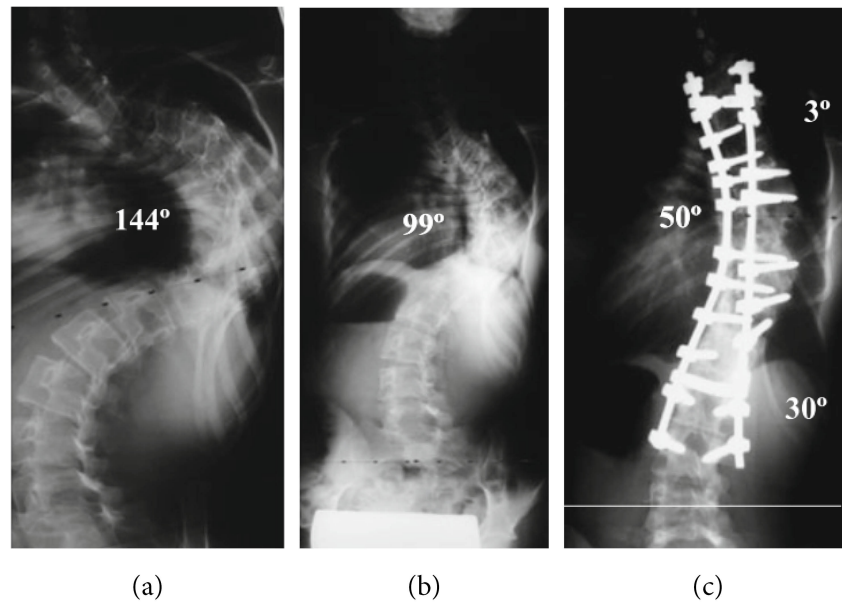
(a) Severe scoliosis with a Cobb angle of 144° . An 'S-shaped' curve is clearly visible in the coronal plane. (b) Reduction of the Cobb angle due to HGT pre-operative to surgery. (c) 3 year follow-up result of spondylosis. Eventually, a reduction from 144° to 50° of the Cobb angle is achieved in this example. CT images are copied from those of Watanabe et al., (2010)[2].
